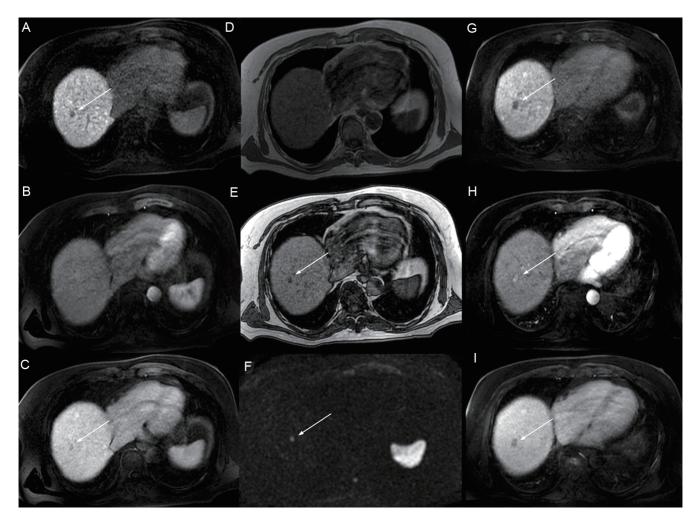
Axial MR images demonstrating a hypointense nodule of 11 mm in the hepatobiliary phase (HBP) located in the liver segment 8. (A–C) It (arrow in A) does not show hypervascularization in the arterial phase (B) but exhibits a washout appearance in the portal venous phase (arrow in C). (E–D) The presence of intralesional fat was documented by the characteristic signal drop on out-of-phase T1-weighted images (arrow in E) since the lesion was not clearly visible in the in-phase T1-weighted images (D). (F) In addition, diffusion-weighted imaging (DWI) showed evident diffusion restriction of the lesion (arrow). (G–I) Follow-up axial MR images of the same nodule performed after 1 year demonstrated a slight increase of lesion size (15 mm vs. 11 mm) (arrow in G) and revealed the appearance of arterial phase hyperenhancement (arrow in H); together with the persistence of washout in the portal venous phase (I), arterial hypervascularization confirmed the malignant evolution to overt hepatocellular carcinoma (HCC).
